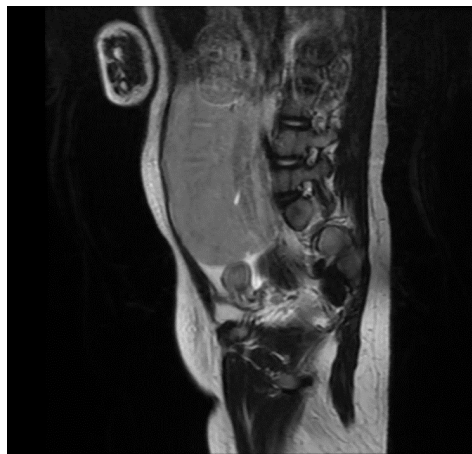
The coronal view of an abdominal MRI
